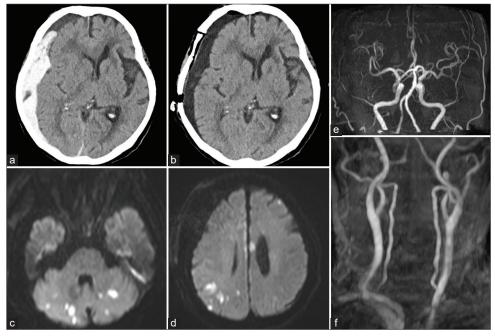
Neuroradiological findings of the case. (a) Plain computed tomography (CT) taken at admission showing a right-sided acute subdural hematoma with low-density areas in some places. (b) CT immediately after surgery showing total subdural hematoma removal and effective intracranial decompression. (c and d) Magnetic resonance imaging taken the day after surgery showing multiple acute cerebral infarctions in the bilateral cerebellar hemispheres, corpus callosum, and cerebral cortex. (e and f) Magnetic resonance angiography showed no vascular abnormalities such as cerebral vascular stenosis, occlusion, or vasospasm.
